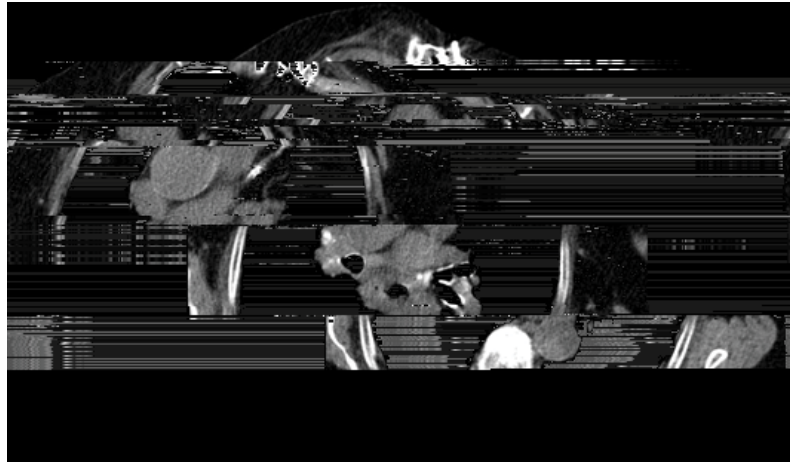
Chest CT, cardiac is migrated into posterior mediastinum.
